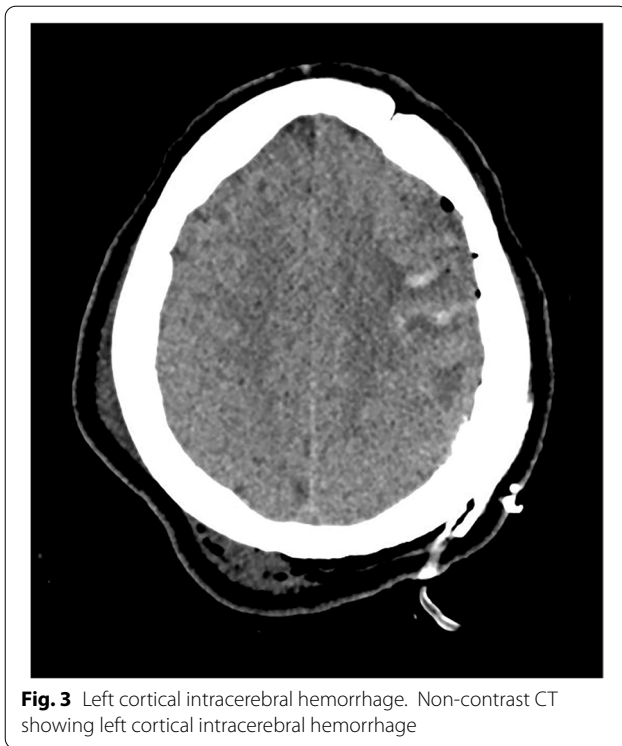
Left cortical intracerebral hemorrhage. Non-contrast CT showing left cortical intracerebral hemorrhage
